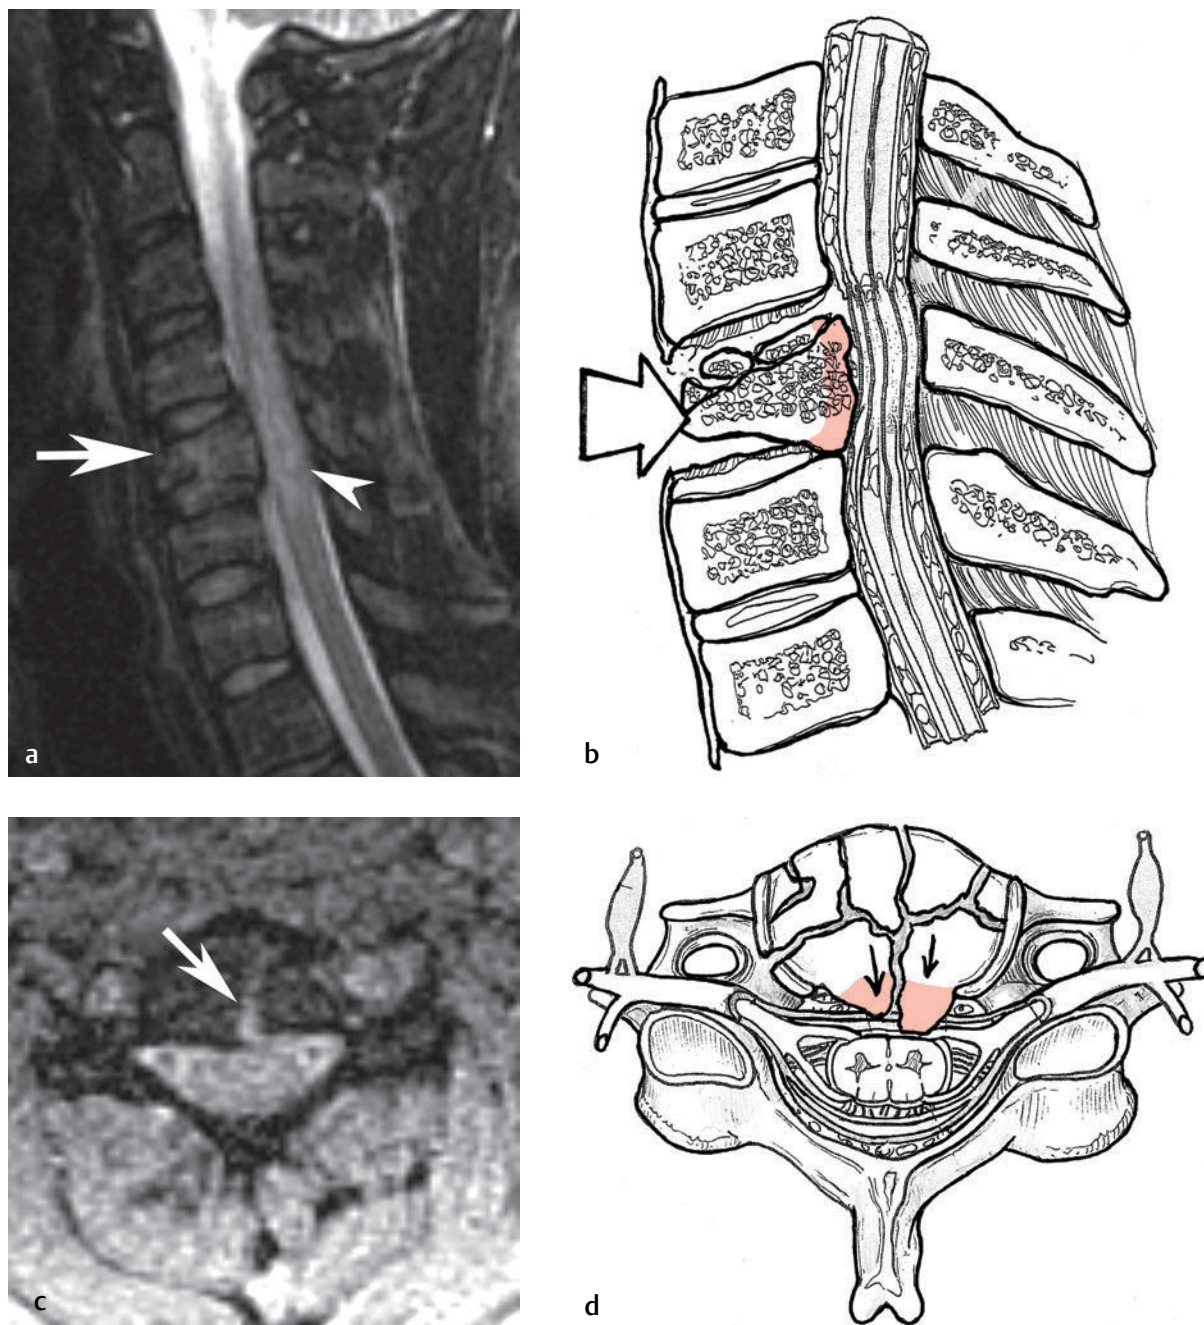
Cervical burst fracture. (a) A sagittal fat-suppressed T2-weighted image and (b) corresponding artist's sketch show a C5 burst fracture (*arrow* on each) with moderate loss of height, retropulsion, and spinal cord contusion (*arrowhead* on a). (c) An axial T2-weighted gradient-echo image and (d) corresponding artist's sketch show the sagittal split component of the fracture (*arrow[s]* on each).[†]
